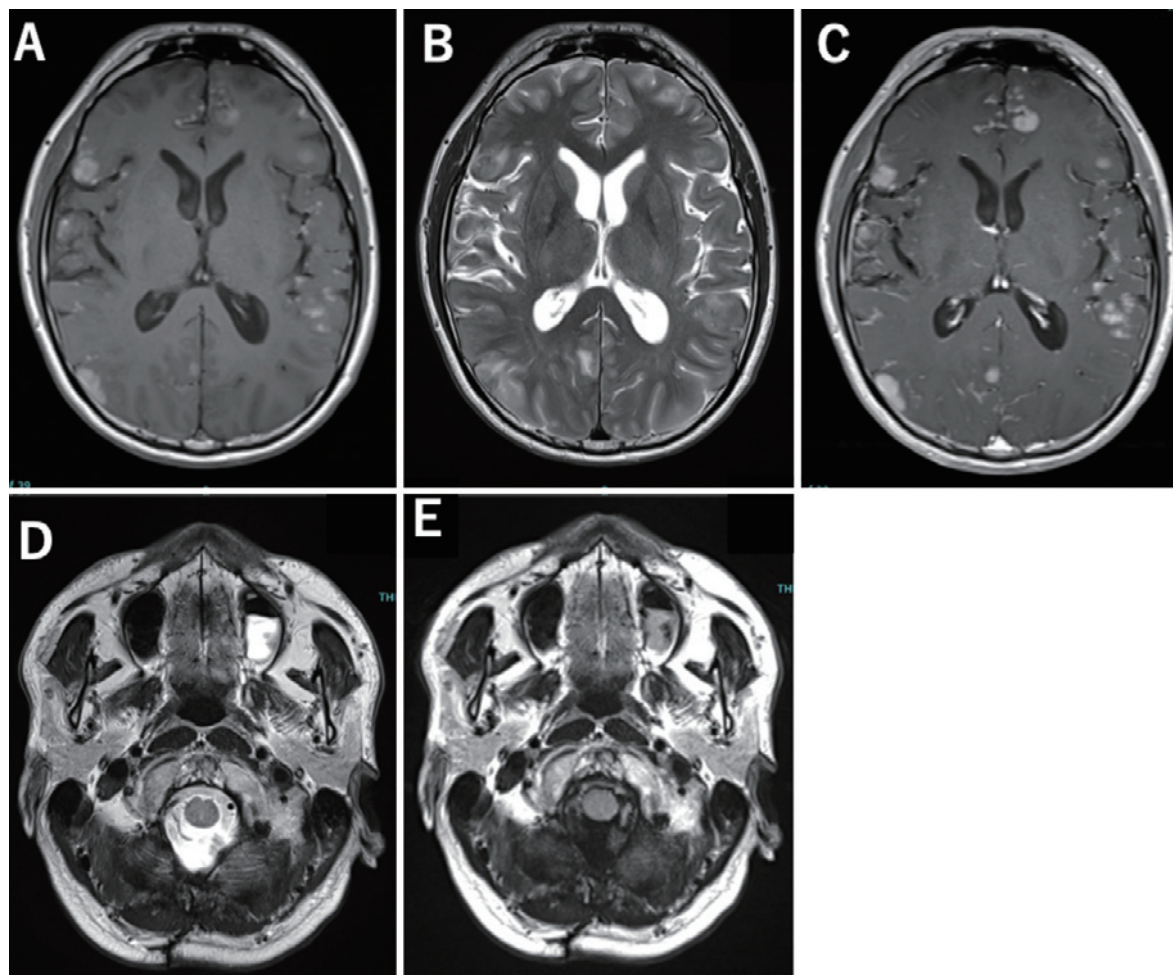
MRI showing multiple lesions and meningeal dissemination. The lesions were hyperintense on axial T1-weighted images (A) and hypointense on axial T2-weighted images (B). (C) Contrast-enhanced T1-weighted image showing no obvious enhancement. (D, E) Axial T2-weighted and gadolinium-enhanced T1-weighted images showing no evidence of recurrence at the site of previous surgery.
